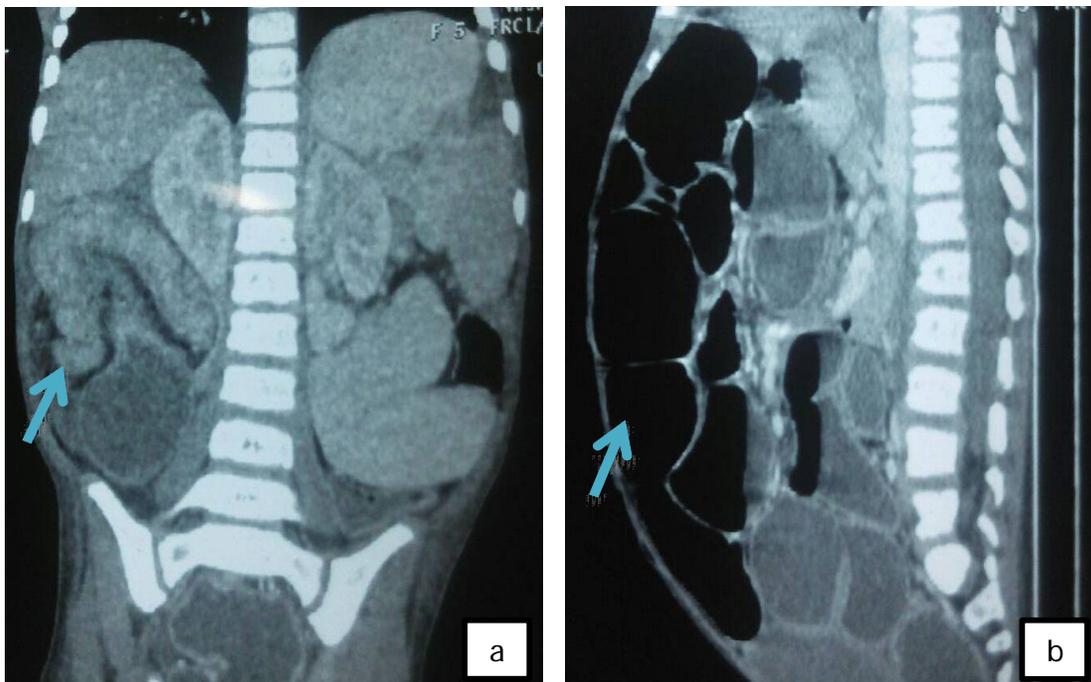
CT scan of the abdomen showing invagination of the ileocolic segment into ascending colon giving a complex heterogenous mass (arrow) in the region of hepatic flexure. Fig 1b: CT scan showing dilated bowel loops with air fluid levels.
